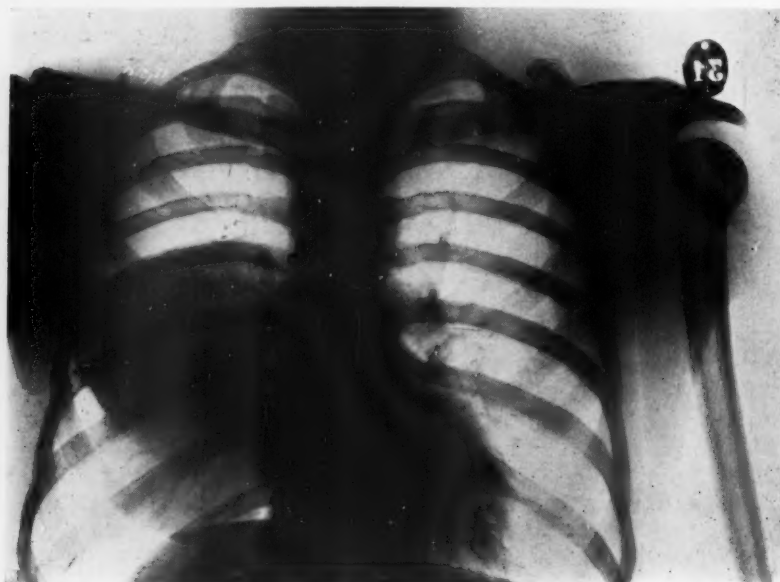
(Case XXVI.) Radiographical image indicating two superposed cysts of the right lung.
